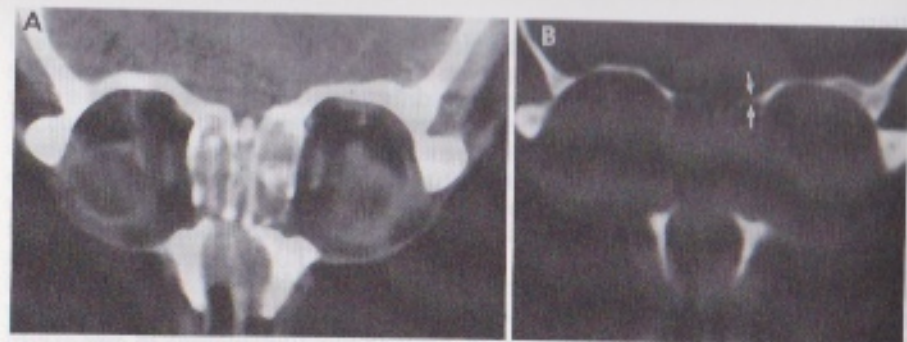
Coronal CT of recurrent polypsis. The soft tissue window (A) reveals the obstruction of the nose and ethmoid by the an extensive mass of polyps. The osseous defects (arrows) in the left ethmoid roof become obvious in the corresponding bone window (B).
